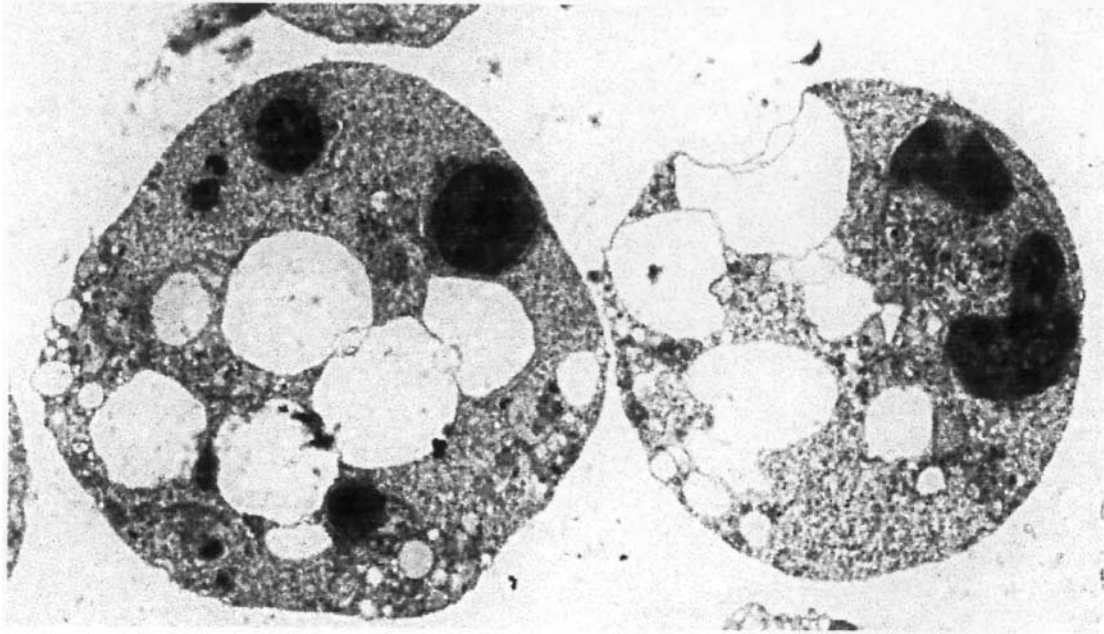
Large vacuoles and apoptotic bodies induced in TK6 cells by Gy x-rays.
